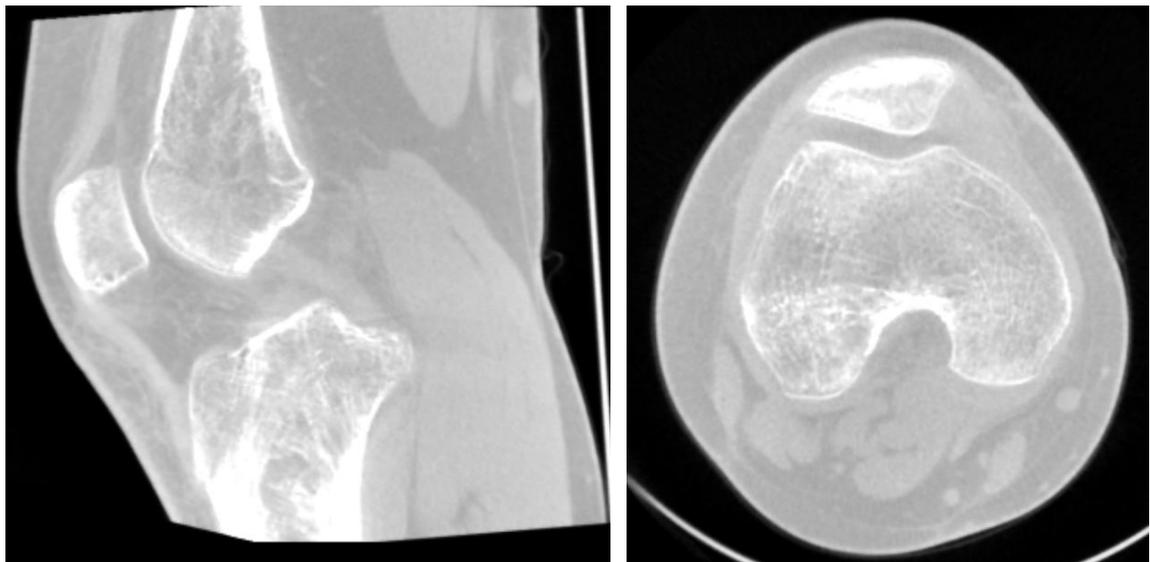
CT was performed to evaluate the final outcomes about two months after operation. Good bone healing was seen. The femoral-patellar joint seemed intact.
